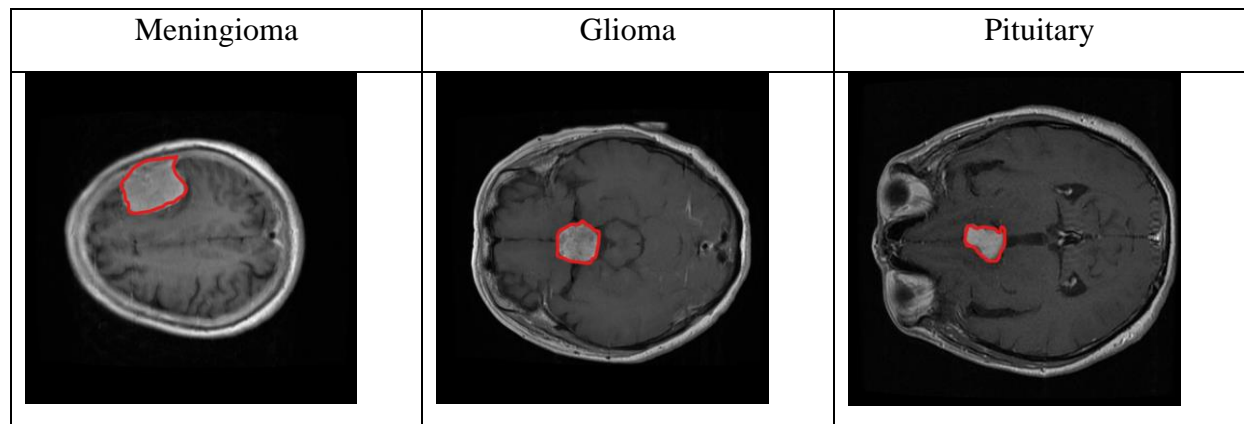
MRI image of the brain tumors.
